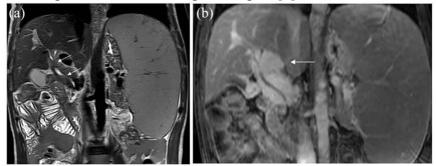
A 36-year-old man with asthenia, abdominal pain, and pruritus. Coronal MR T2-weighted image (A) and contrast-enhanced MR T1-weighted image (B) show multifocal smooth strictures of the common bile duct (arrows) because of extrinsic compression by a portal cavernoma (B, arrow) developed secondary to an extrahepatic portal stenosis. Diagnosis was primary myelofibrosis associated with portal hypertensive cholangiopathy [1].
